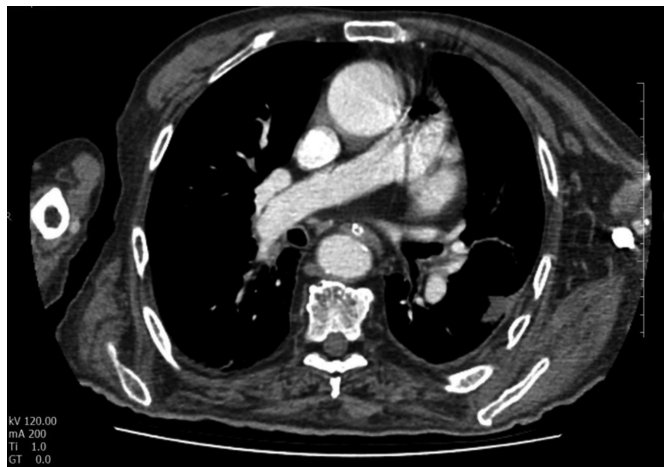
Contrast-enhanced axial CT scan of chest. Air is seen in the pulmonary artery.
